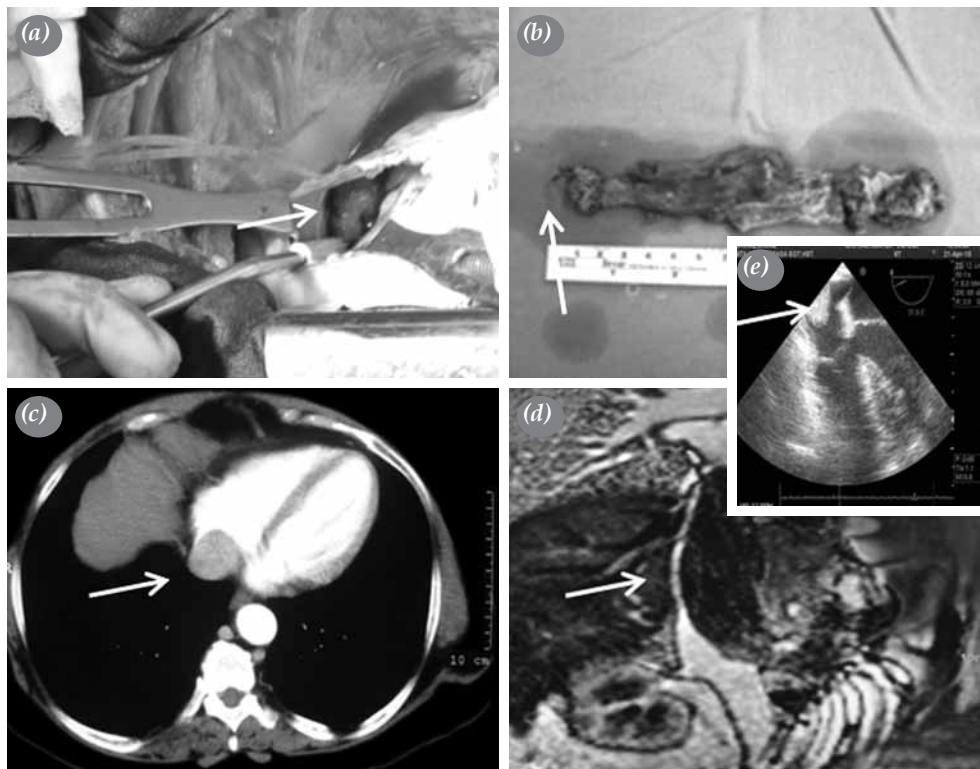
(a) Intraoperative right atrial tumor thrombus. (b) Total resection of tumor thrombus mass with prolene marker suture. (c) Computer tomography view. (d) Magnetic resonance view. (e) Trans thoracic echocardiography view.
